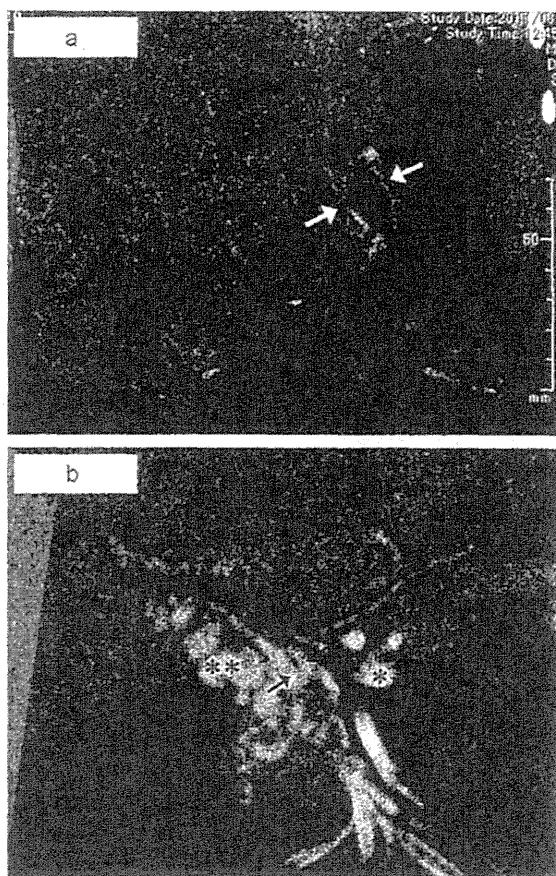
(a) Large PV thrombosis (white arrow) in coronary view revealed by computed tomography. (b) Thin and long PV thrombosis (black arrow) from the bilateral portal branch to the confluence of the SMV and the SpV (asterisk). A collateral vein was present in the hepatoduodenal ligament (double asterisk).
